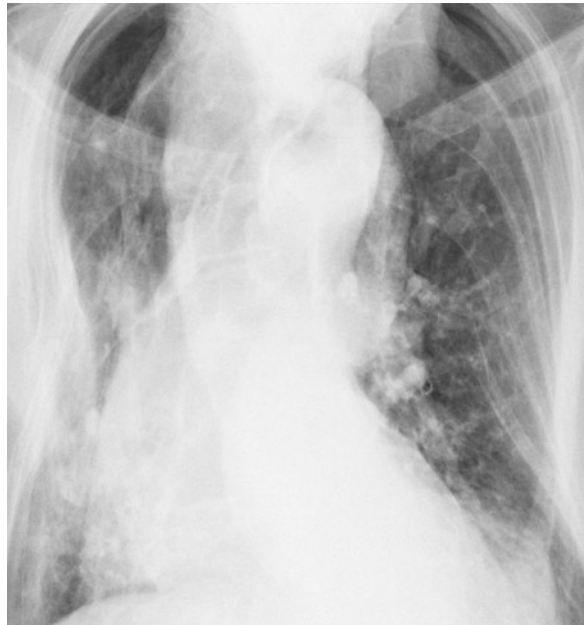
Posterior–anterior chest X-ray. Significant distortion of the chest caused by a large hiatal hernia with displacement of the entire stomach into the chest
